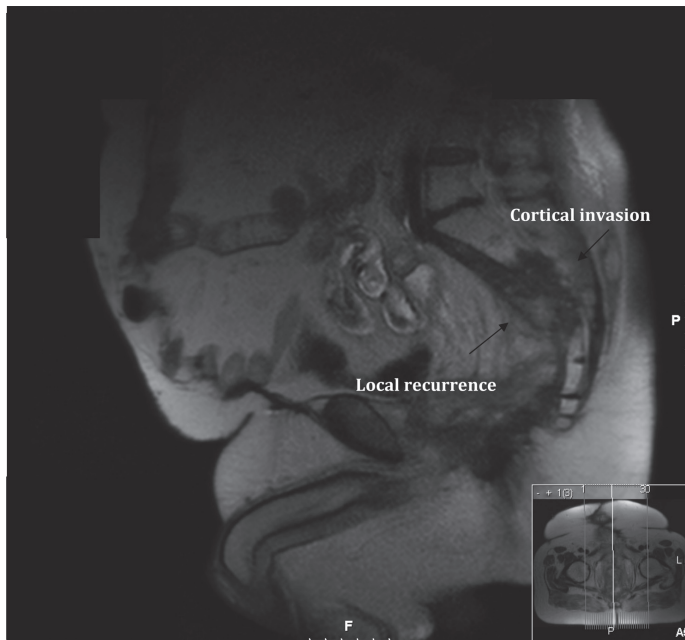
MRI: recurrent rectal cancer with cortical invasion in sacrum
